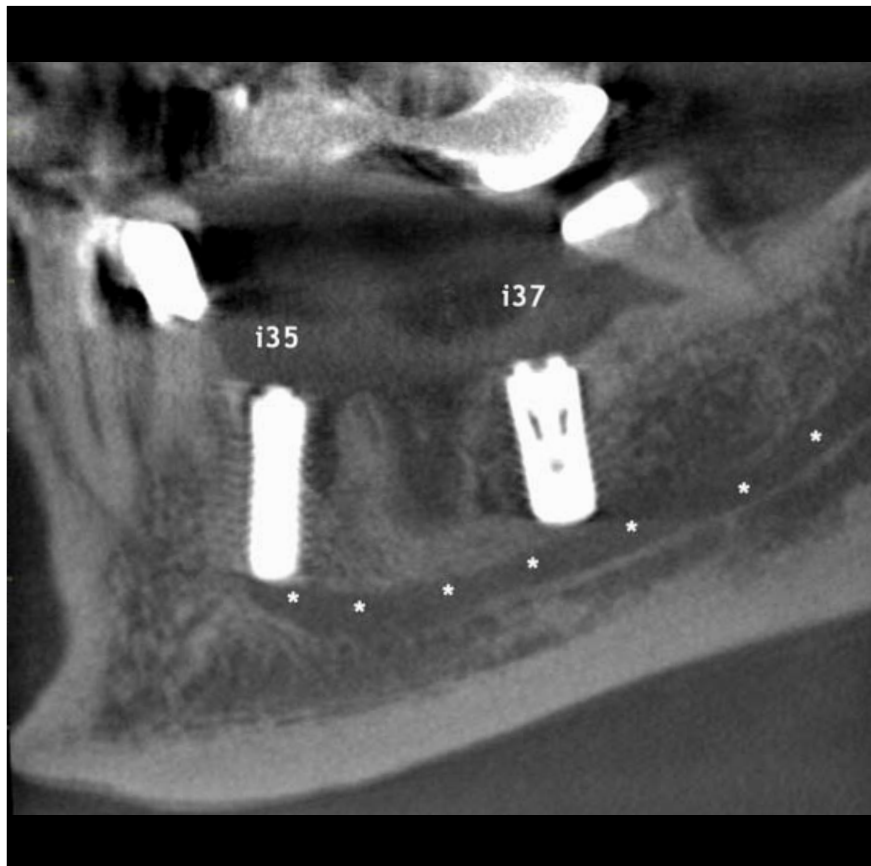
Patient referred for evaluation neurosensory disturbances in the region of the mental nerve following implant placement in the second premolar (i35) and second molar (i37) region of the left posterior mandible. The CBCT images show that i35 is inserted partially into the mandibular canal and mental foramen region.
